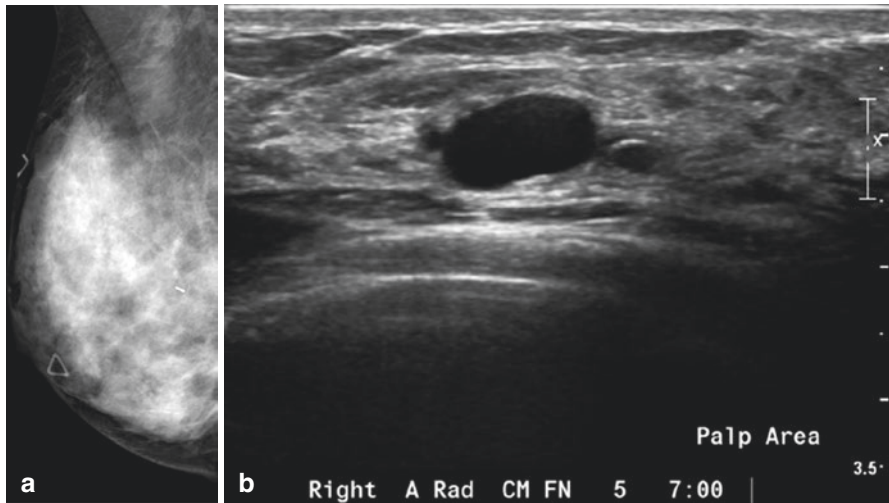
(a) Right MLO view mammogram. (b) Right targeted breast ultrasound
